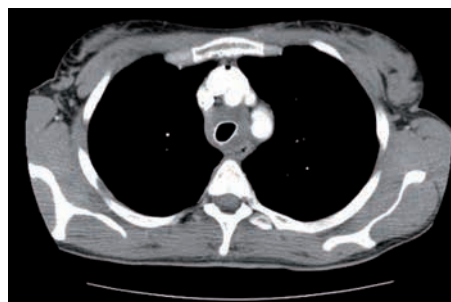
CT scan (above) and reconstructions in frontal and sagittal view (below) showing stent in the distal trachea and no signs of distant spread of the tumour.
